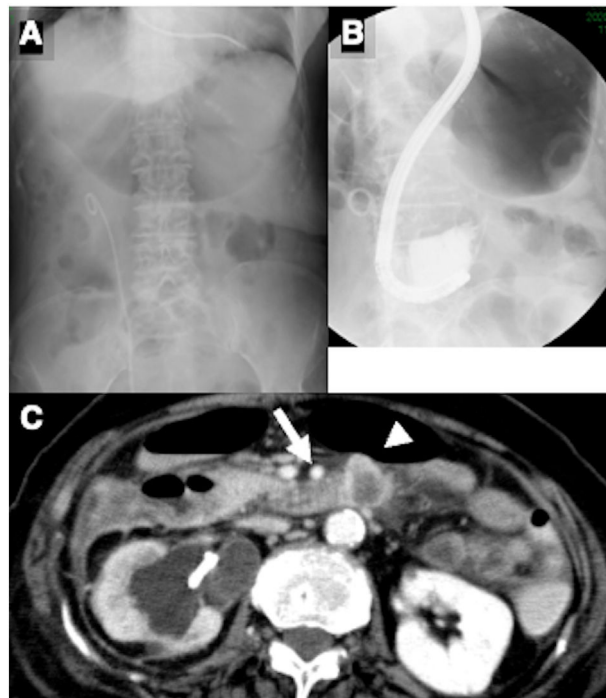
(A) X-ray shows double bubbles which are dilatation of the stomach and duodenum. She was also treated with pacemaker placement and a ureteral stent. (B) Single balloon endoscopy revealed normal mucosa at the obstruction. Neither diatrizoate nor the catheter from single balloon endoscopy could pass through the obstruction. (C) Contrast-enhanced computed tomography shows the obstructed duodenum sandwiched between the aorta and superior mesenteric artery (arrow) and a mass showing marginal enhancement (arrowhead).
